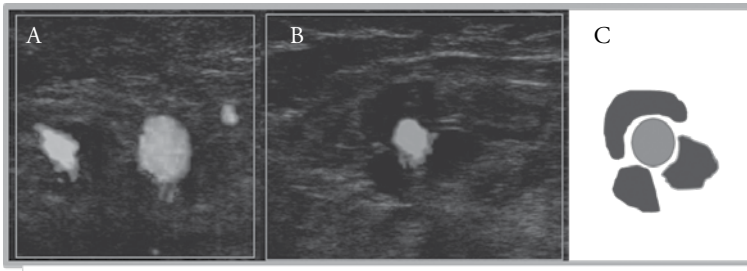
Cross-sectional ultrasound view of (A) dilated, refluxive vein, (B) after hyaluronan injection, (C) scheme. The horizontal gaps indicate the saphenous ligaments
